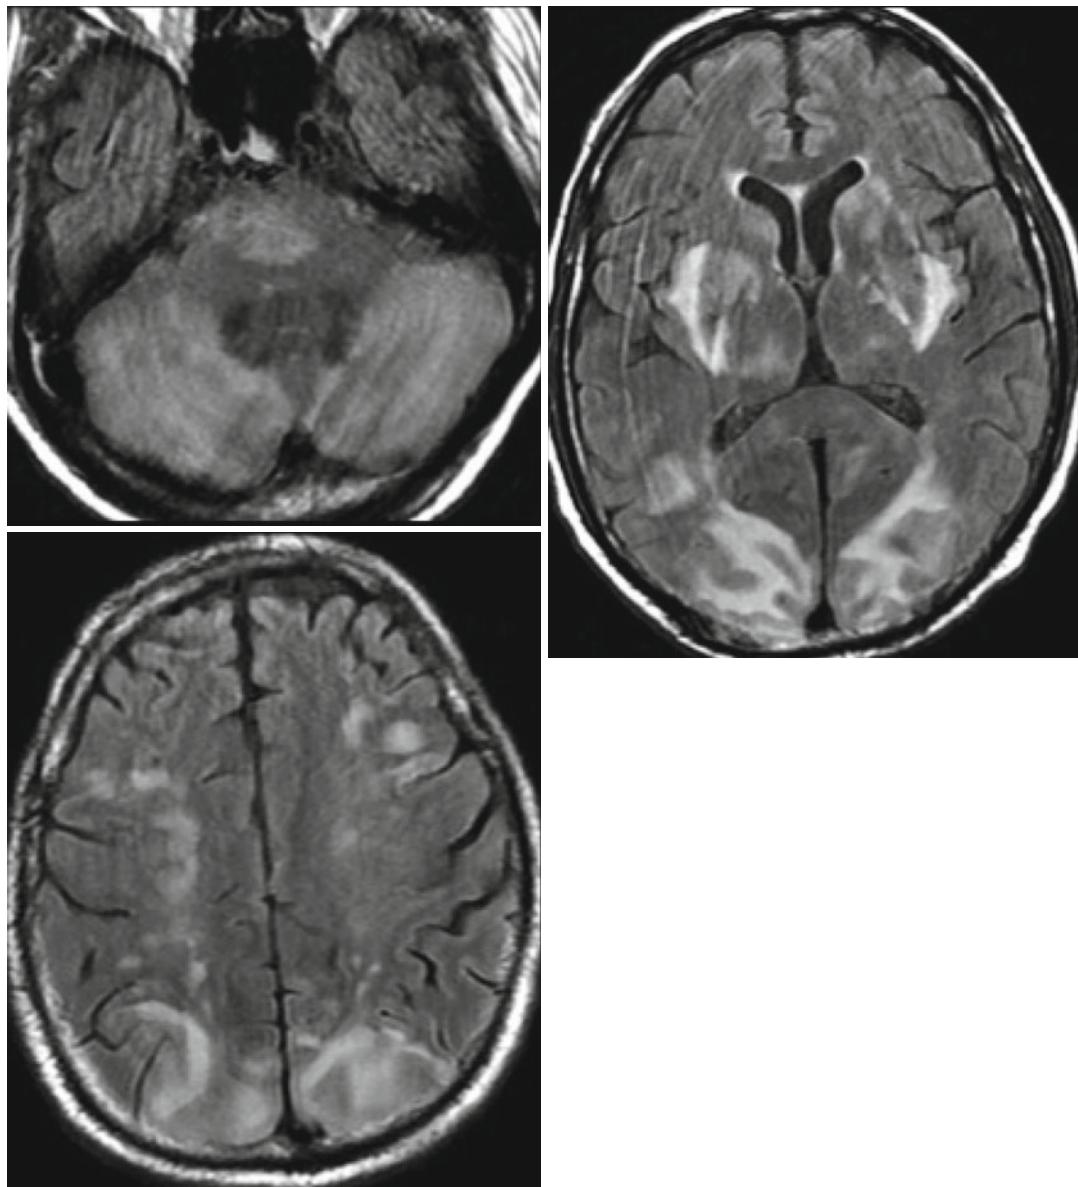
FLAIR images in a patient presenting cyclosporin-induced PRES. Symmetric and extensive vasogenic edema in the posterior fossa, temporo-occipito-parietal regions, frontal watershed zones, and basal ganglia
